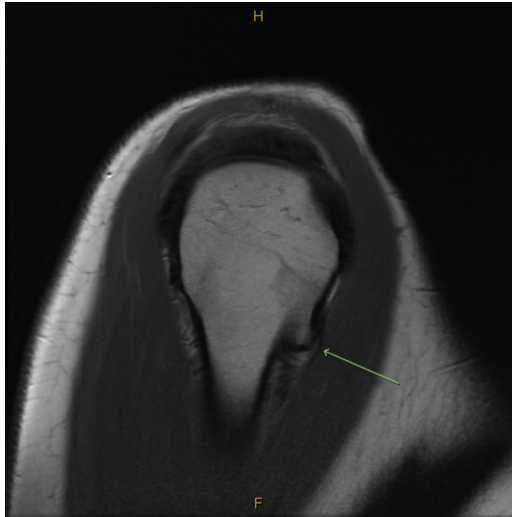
T1 parasagittal MRI right shoulder, the green line measuring subacromial osteochondroma. MRI, magnetic resonance imaging.
